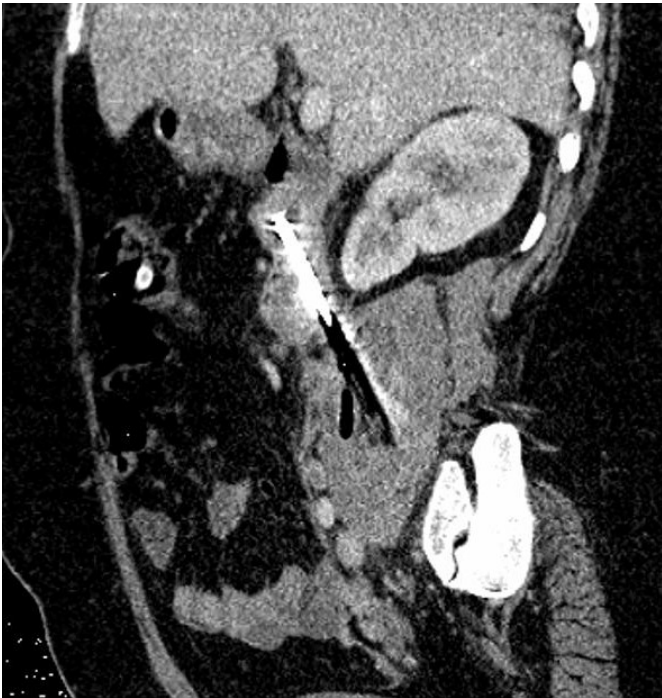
Abdominal computed tomography image of the patient
